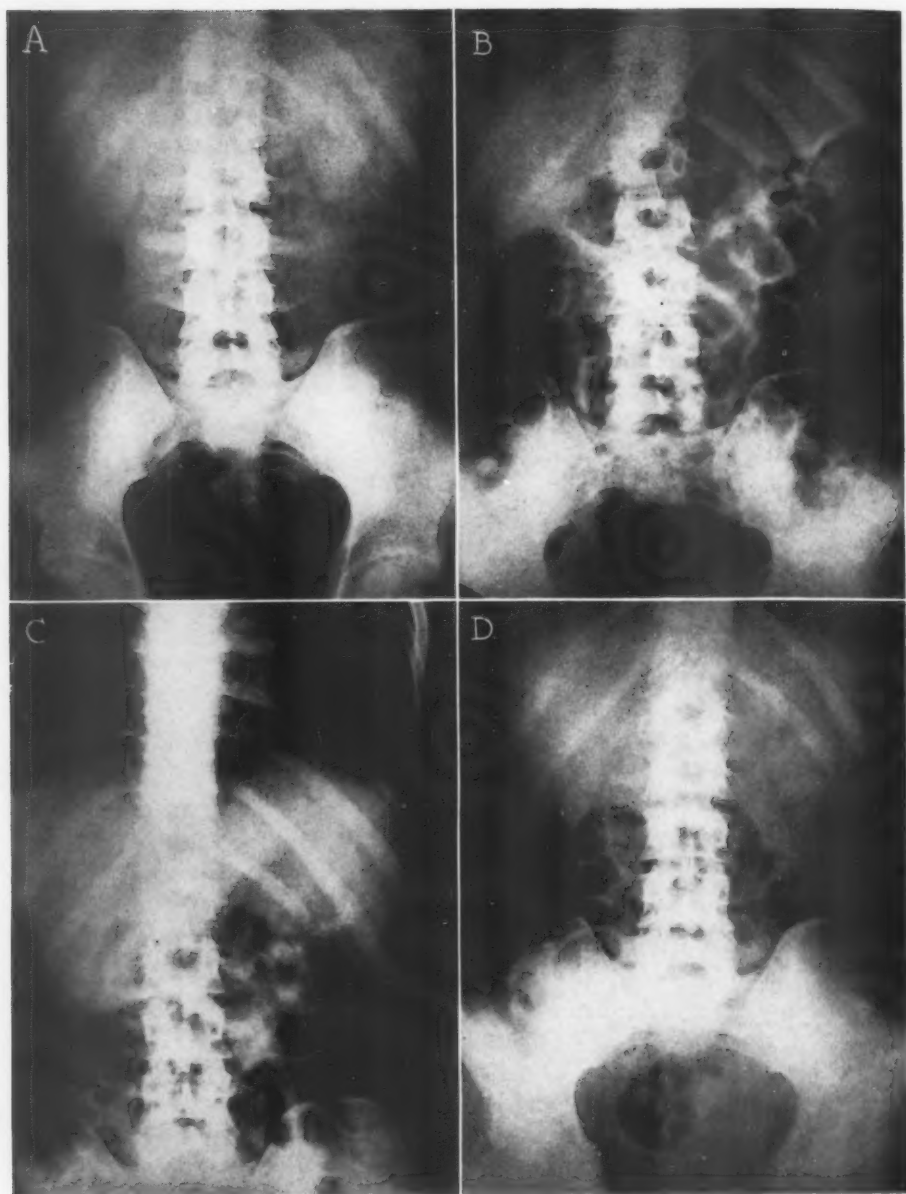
Roentgenograms showing rapid passage of 2000 cc. of air. (W. H.) (A.) Initial film showing only a small amount of gas in the cecum, descending colon and rectum. (B.) At 17 min., 1000 cc. of air had been aspirated. The stomach and intestines are considerably dilated. The first flatus had just been passed. A previous film at 8 min. showed the air had reached the cecum. (C.) At 37 min., 2000 cc. of air in and flatus was being freely passed. (D.) At 110 min., there is relatively little of the gas left, flatus having been voluminously passed for 93 minutes.
